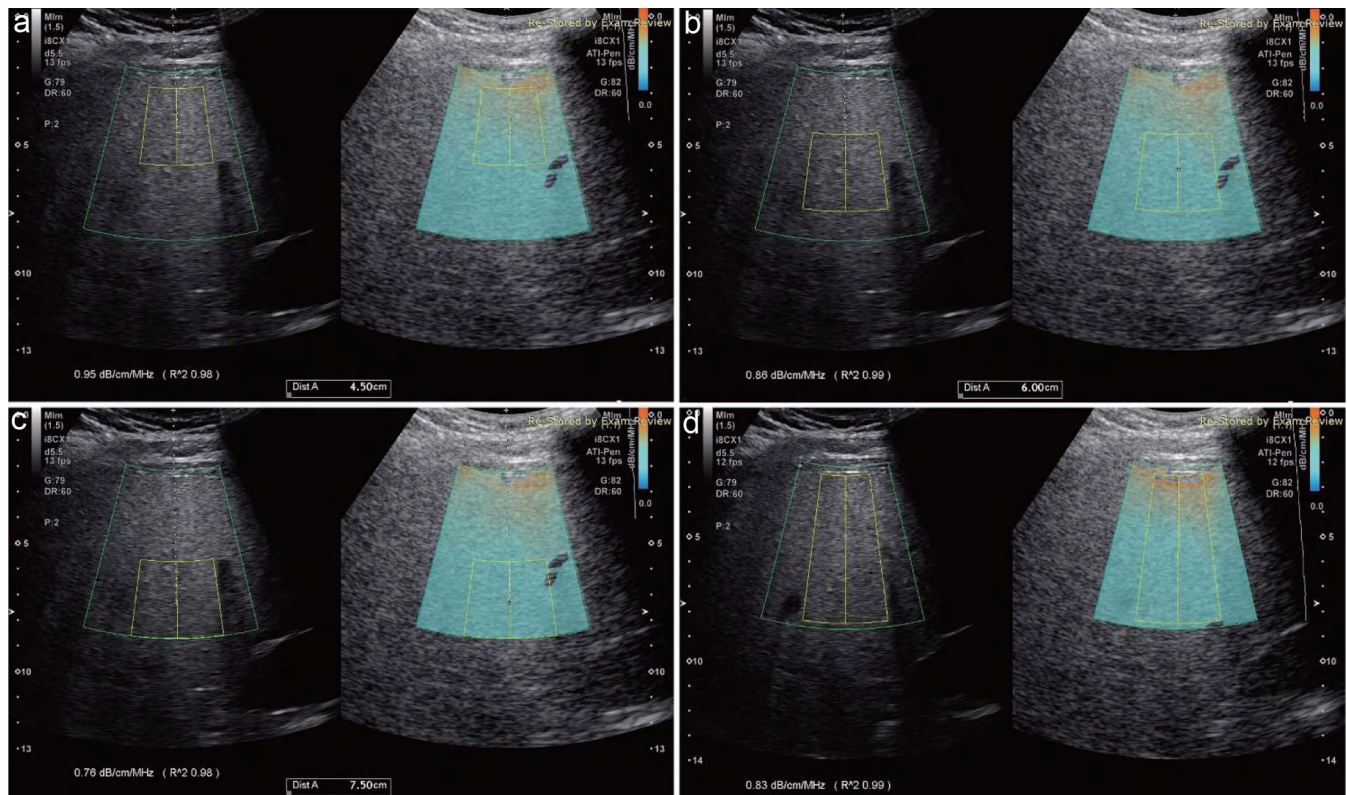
Ultrasound attenuation coefficient (AC, dB/cm/MHz) is measured using two sizes of the region of interest (ROI). A ROI (3 cm tall × 3 cm wide) is placed at the depths of 4.5 cm (the distance from the skin to the center of ROI (a), 6 cm (b), and 7.5 cm (c) in the liver. A larger ROI (d), 6.5 cm tall, 4 cm top border, and 7.3 cm of bottom border) is also used to measure AC of the liver. The AC value is 1.06 dB/cm/MHz, 0.86 dB/cm/MHz, 0.66 dB/cm/MHz, and 0.85 dB/cm/MHz measured at the depths of 4.5 cm, 6 cm, 7.5 cm, and with a large ROI, respectively. AC, attenuation coefficient; ROI, region of interest.
